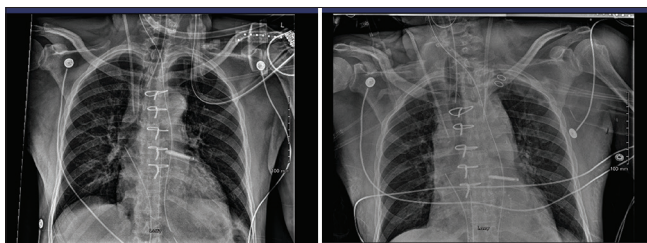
Chest radiographs showing the right internal jugular vein catheter placement in the OR (left) and the subsequent left internal jugular vein catheter placement postoperatively in the SICU (right)
